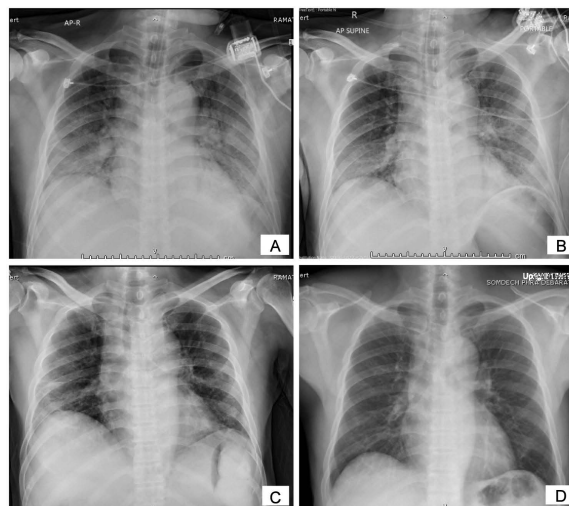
Chest radiography on the first day show patchy opacity predominate at both lower lungs zone with air bronchogram, (A). After PJP, Nocardia, and CMV pneumonia was diagnosed and continued treatment (B). At discharge date chest radiograph shows focal patchy opacity remains at right lower lung zone (C). After 6 months follow up chest radiography shows complete resolution of pneumonia (D).
